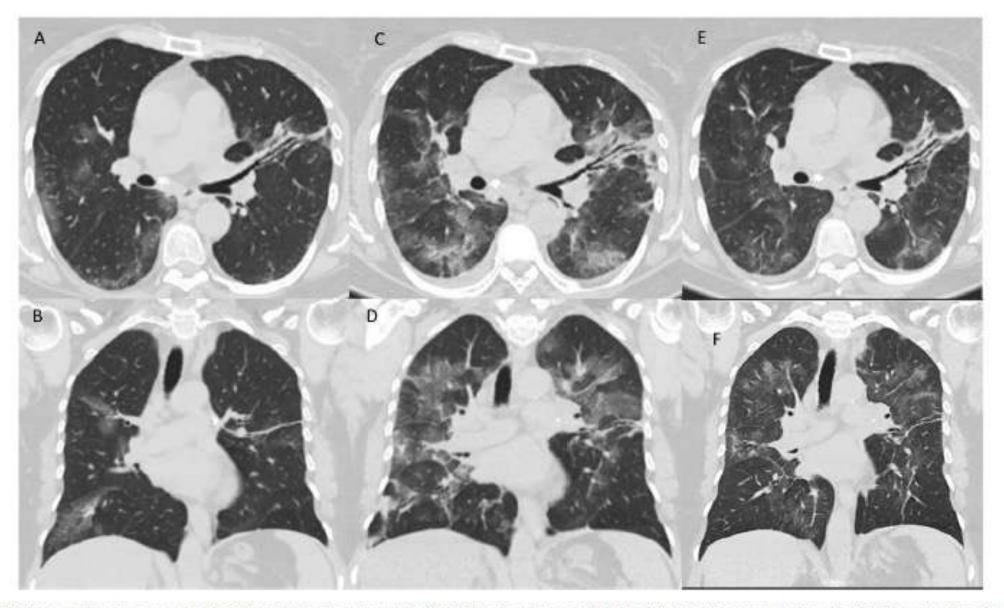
A 59-year-old woman with Covid-19. Same level of mid-axial (A, C and E) and mid-coronal (B, D and F) chest CT scans on admission (A-B), on the day of tocilizumab given because of requirement of oxygen support and progressive lung imaging (C-D) and 7 days after onset of tocilizumab (E-F), retrospectively.
